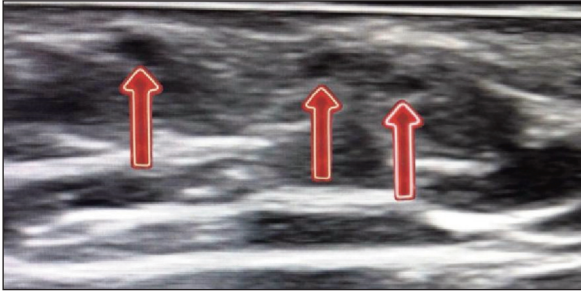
Diagnostic ultrasound imaging of the transverse view of the cord.
